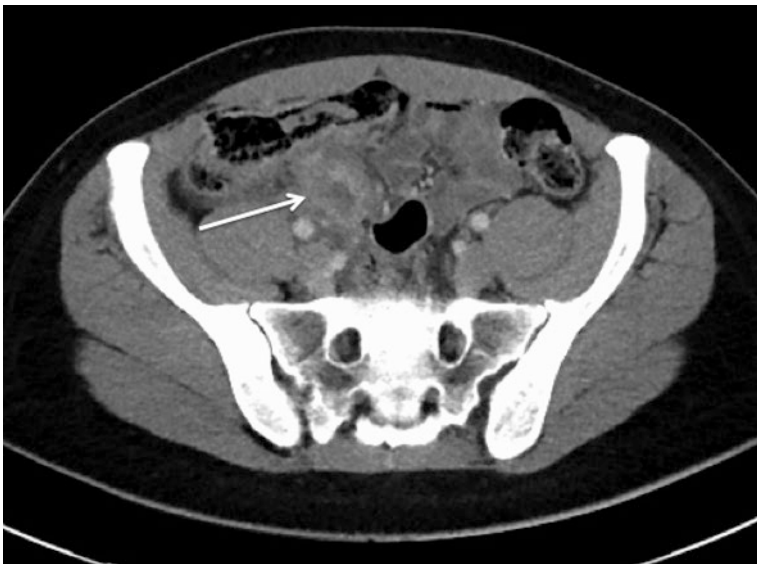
A 23-year-old man presents with a four-day history of right iliac fossa pain and is tender and guarding on examination. Axial contrast-enhanced CT abdomen/pelvis demonstrates an inflammatory soft tissue mass in the right iliac fossa, in keeping with acute appendicitis with phlegmon formation
